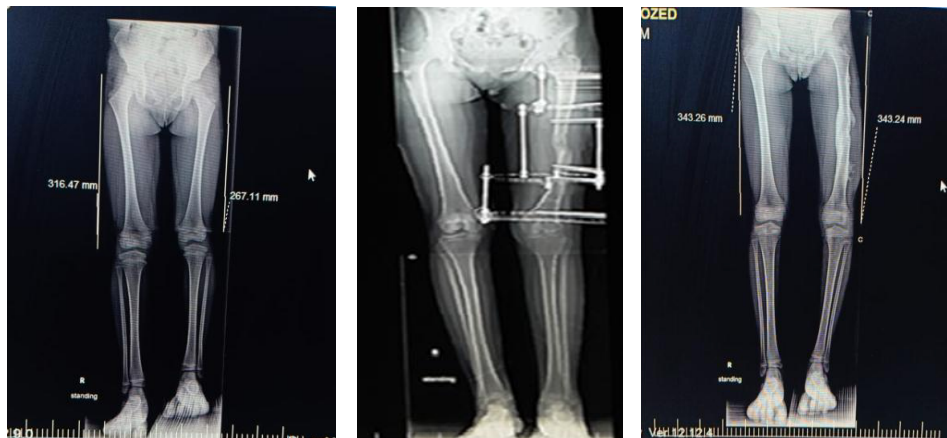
Radiograph of 9 years old female with 5 cm left femoral shortening.
